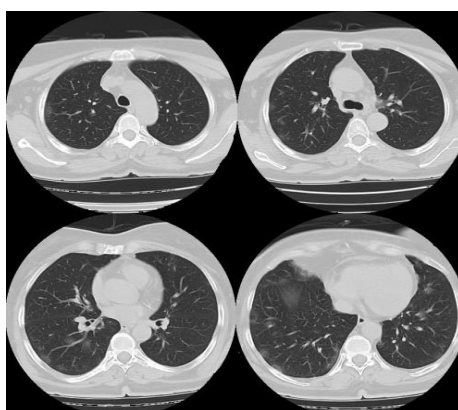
Mild lung involvement image on CT
